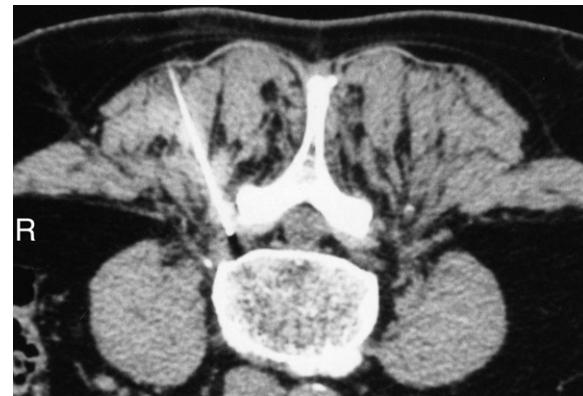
CT axial image at the L4–5 level showing the CT guided placement of a 22 gauge spinal needle with the tip at the right L4 perineural region.
